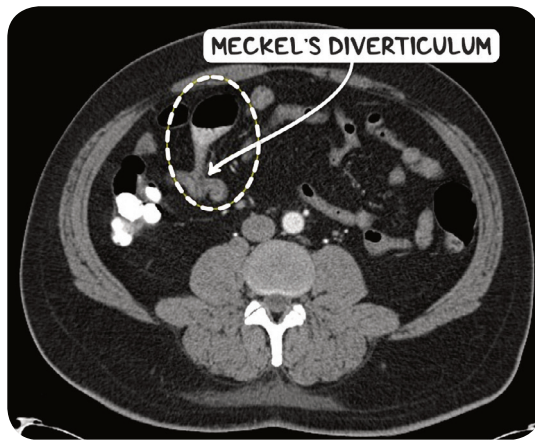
A CT scan in the axial plane demonstrating a Meckel's diverticulum.
